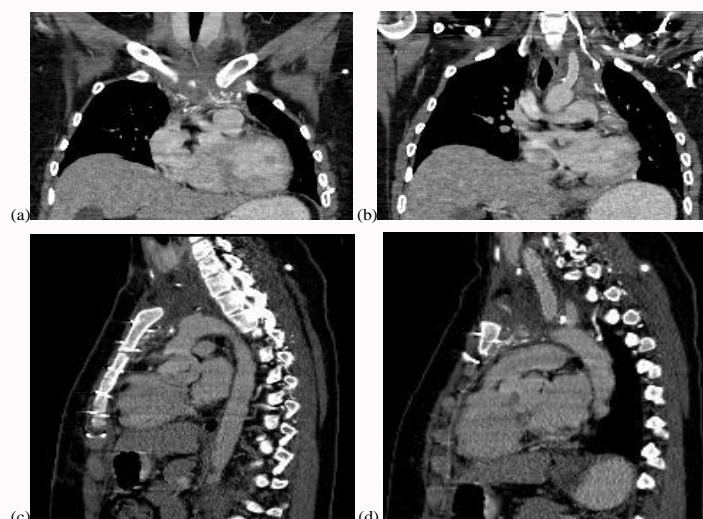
Post-operative contrast-enhanced CT examination after resection of the large mediastinal mass with extrathoracic extension into the neck. There is normal positioning of the left lobe of the thyroid (a). The trachea is near midline (b). There is normal contrast opacification of the aortic arch and left common carotid and subclavian arteries, which are no longer displaced posteriorly (c, d). Note the left common carotid artery bypass graft (b, d). However, also note the abnormal ill-defined isoattenuating soft tissue surrounding the great vessels in the upper mediastinum (a-d).
